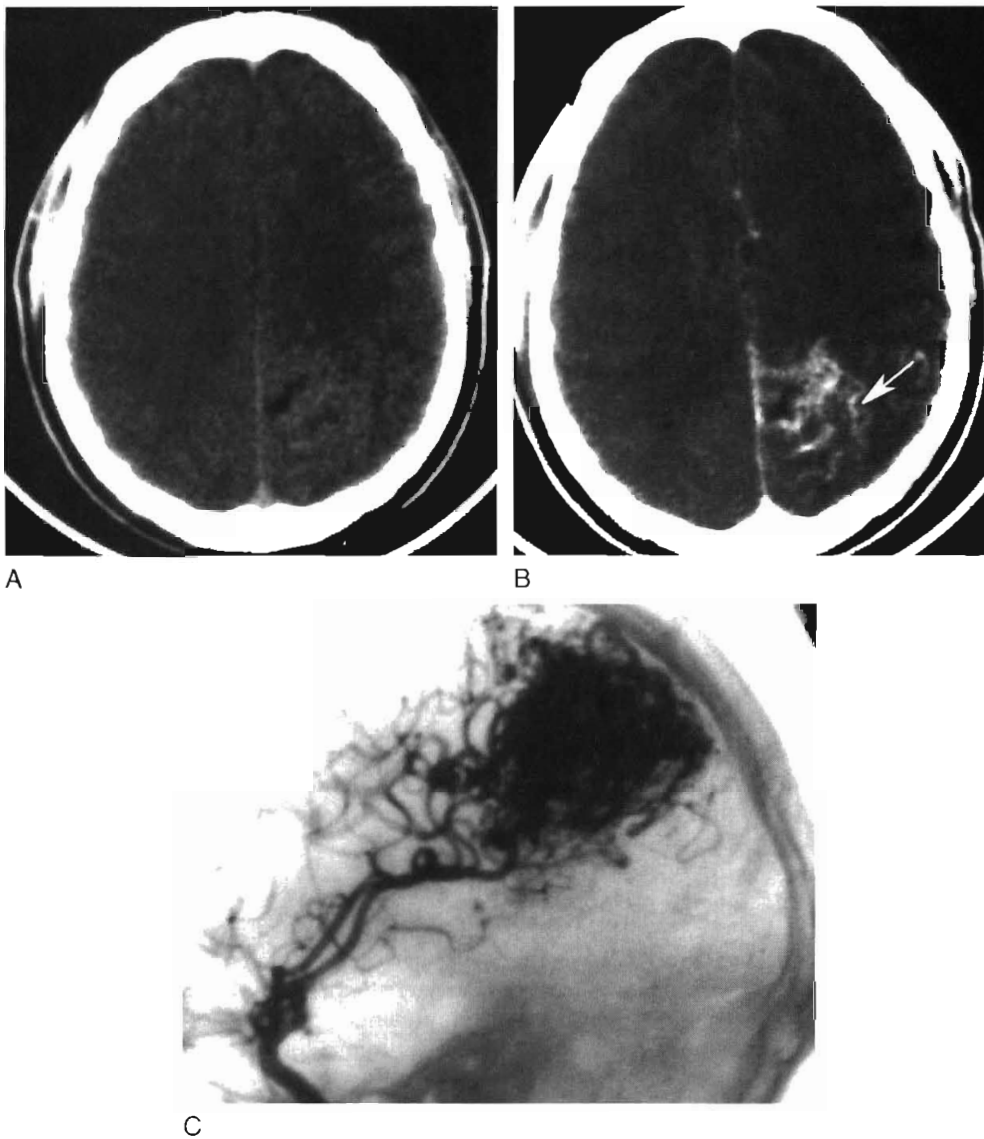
Arteriovenous malformation. *A*, Axial non-contrast-enhanced CT scan of the head reveals a vague area of hyperdensity in the posterior left parietal region. *B*, Contrast-enhanced CT scan demonstrates serpiginous enhancement of this lesion (*arrow*). *C*, Internal carotid artery angiogram demonstrates an arteriovenous malformation being fed by the middle cerebral artery.
